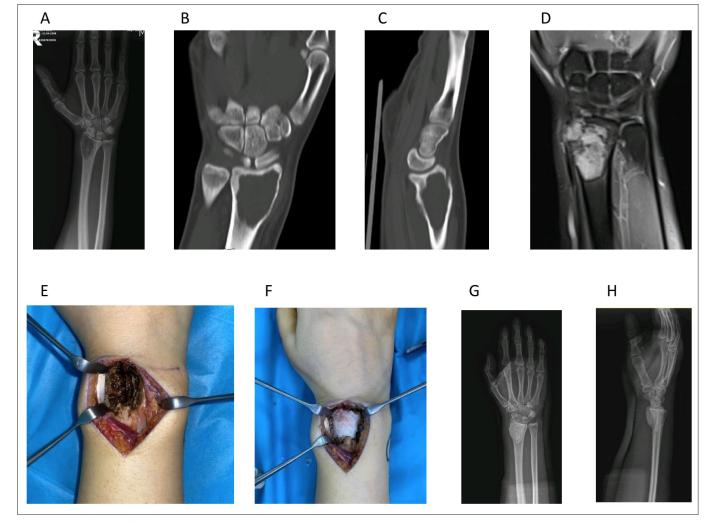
A 24-year-old female with distal radius giant cell tumor: a) preoperative plain radiograph, b,c) preoperative computarized tomography d) preoperative magnetic resonance image, e,f) the patient underwent curettage followed by cementation, g,h) postoperative plain radiograph.
